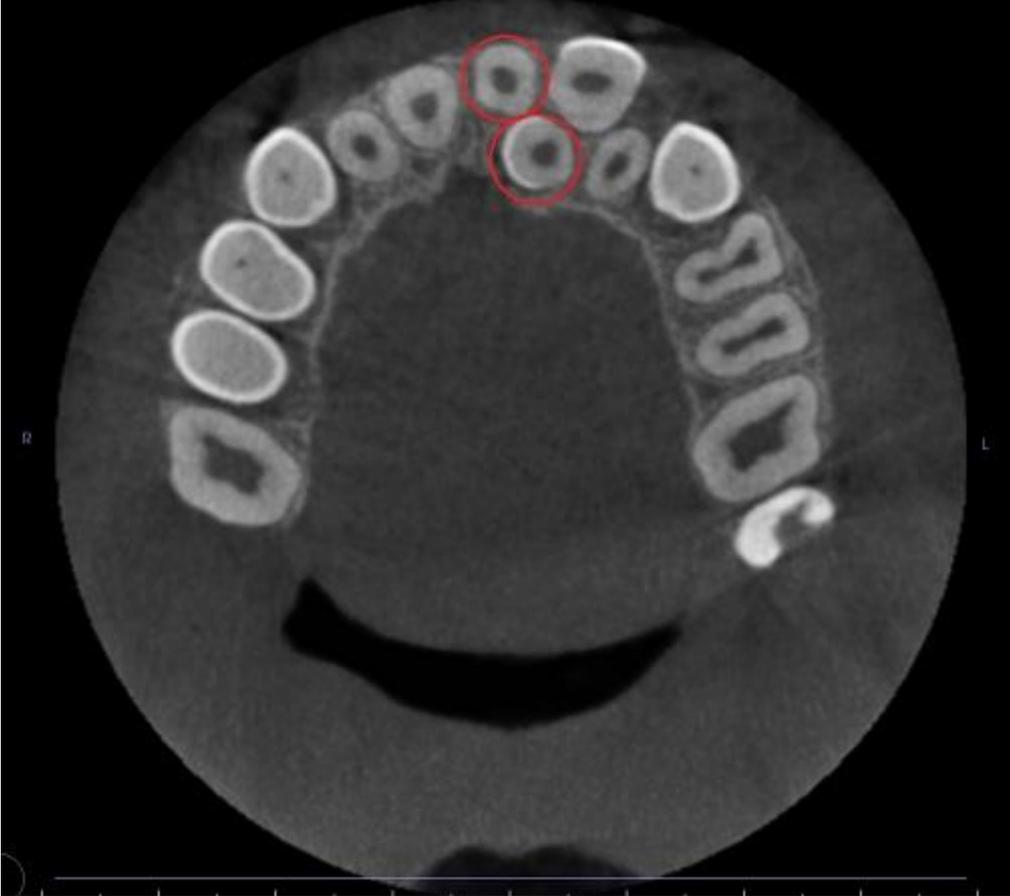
Axial slice of the CT with visible mesiodens and supernumerary tooth
